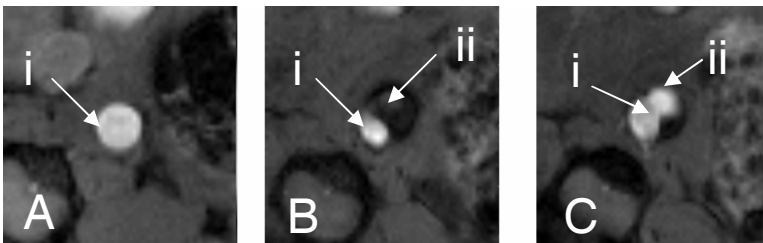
MR images of transverse cross-sections of the abdominal aorta. A) At baseline, the aorta (i) appears concentric and no aneurysm is present. B) The aorta appears compressed due to the presence of an aneurysm. The aneurysm (ii) appears dark compared to the bright blood within the aorta, indicating remodeling of the adventitia with no medial break. C) Bright signal indicates there is a break in the medial wall of the aorta (i) allowing blood to flow into the aneurysm (ii).
